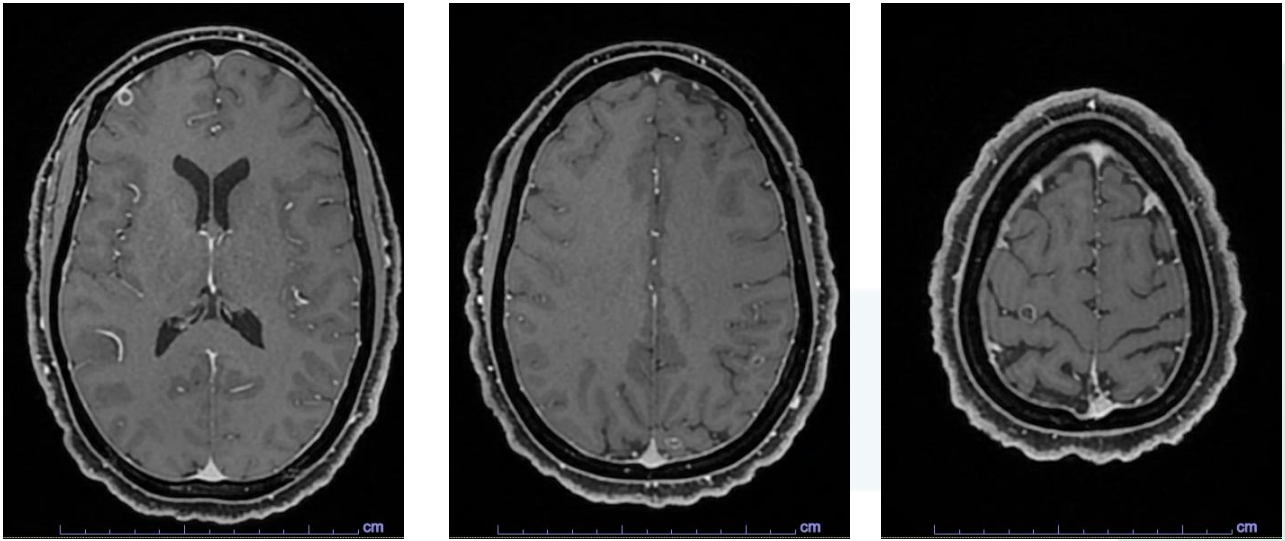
Ring enhancing lesions on MRI
